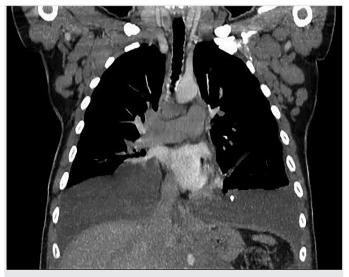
Computed tomography image during diagnosis: bilateral chylothorax
